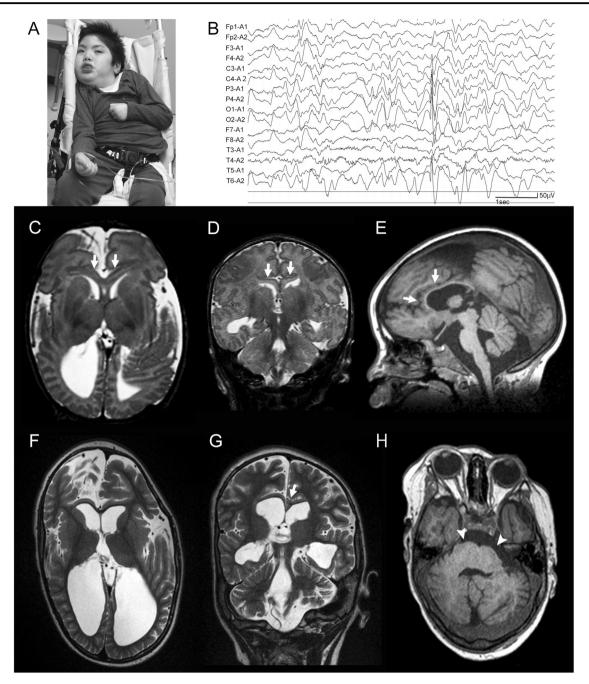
Cranial and digital features in the patient. a A clinical photograph at 6 years and 5 months old. b Interictal electroencephalogram at 4 years and 3 months old shows the 2–3 Hz spike-and-waves in the bilateral central, parietal, and posterior areas with a slow wave-dominant background. c, d Axial c and coronal d T2-weighted images obtained at 1 day after birth. A thick supracallosal gray matter across the midline interhemispheric fusion (arrow) and irregularly enlarged bilateral posterior ventricles can be observed. e–h Brain MRI taken at 4 years and 3 months old. e Sagittal T1-weighted image shows a small
